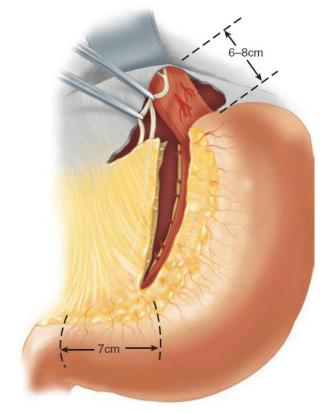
Highly selective vagotomy. (Reproduced with permission from Zinner MJ Schwartz SI, Ellis H: Maingot's Abdominal Operations, 10th ed. Vol. I. Stamford, CT: Appleton & Lange; 1997.)
